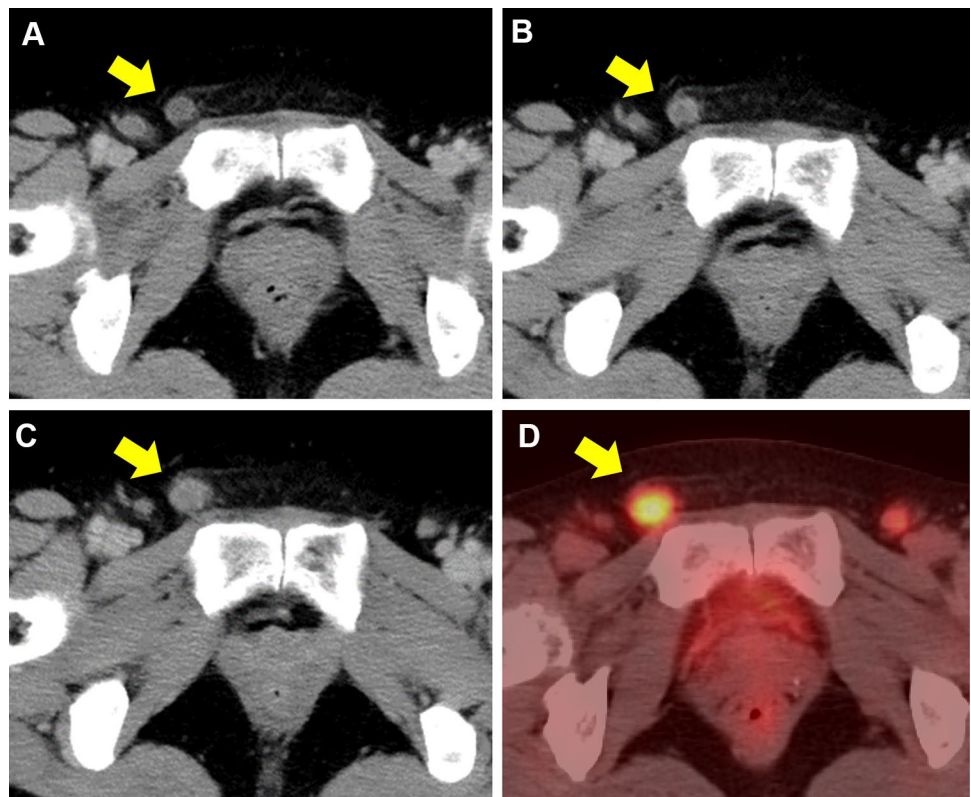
a–d Fluorodeoxyglucose-positron emission tomography-computed tomography showing an inguinal and vulvar mass and lymph node metastasis (yellow arrow) 6 months later initially noted
